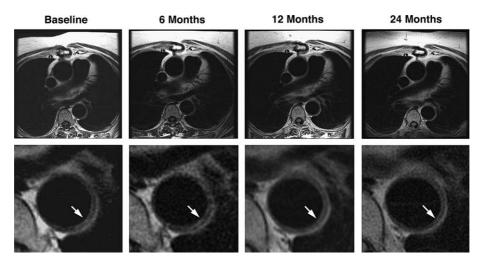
Effect of lipid-lowering by simvastatin on human atherosclerotic aortic lesions. T2-weighted magnetic resonance images of the same patient scanned at different time points (baseline and 6, 12, and 24 months after simvastatin) and detail of the descending aorta (bottom). A significant reduction in vessel wall area and plaque thickness without changes in the lumen was demonstrated after 12 months of treatment. The arrow indicates the maximal plaque thickness.
